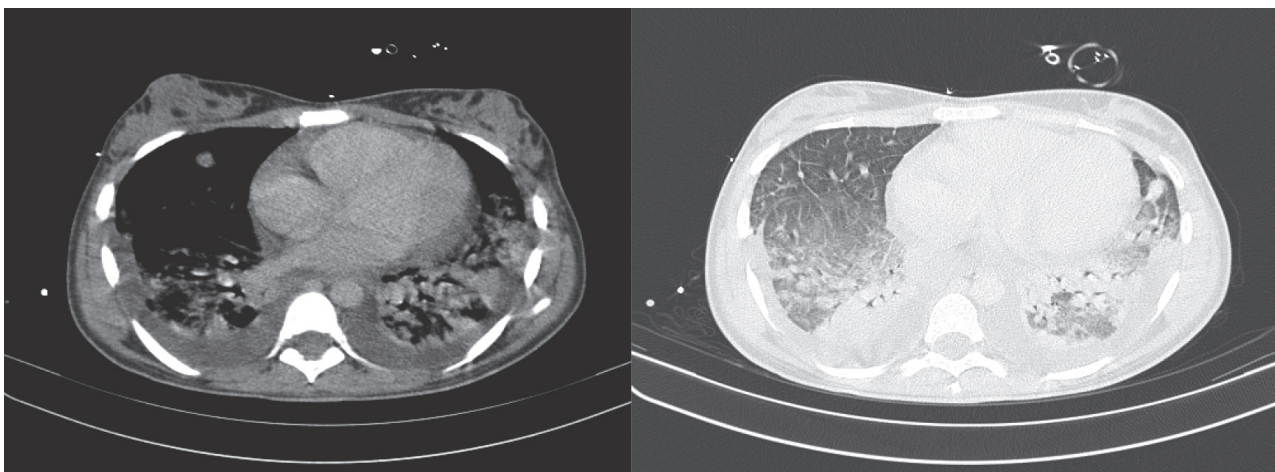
Computed tomography angiography showing massive pulmonary thromboembolism.
